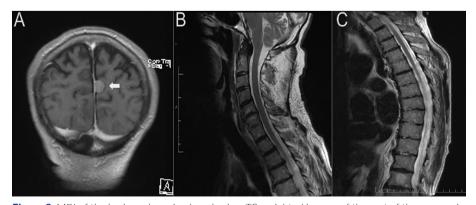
MRI of the brain and cervicodorsal spine. T2-weighted images of the rest of the neuroaxis, (A) coronal brain, (B) sagittal cervical spine, (C) sagittal dorsal spine, where there are no other findings related to the lesion under study; it only shows an image compatible with meningioma (arrow) in the left medial parietal region in close contact with the brain sickle.
